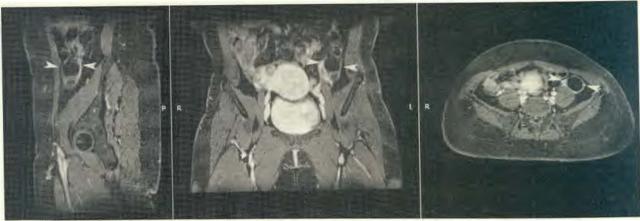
MRI of the pelvis: To the left, this appears contiguous with several thin-walled, fluid-equivalent foci in the left adnexal region. The largest cyst measures about 2.7cm x 2.5cm x 2.9cm (CC x T x AP). No definite canal is detected.
